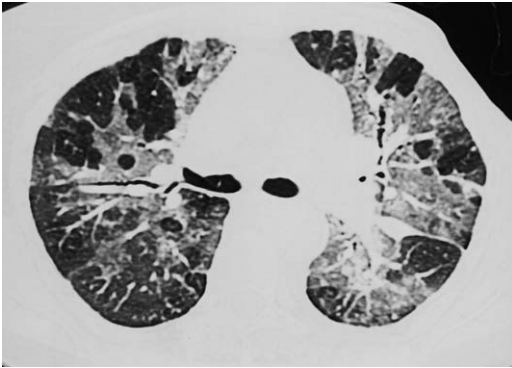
NSIP in a 75-year-old woman taking cytoxan. HRCT shows bilateral patchy ground-glass opacities and absence of honeycombing.
